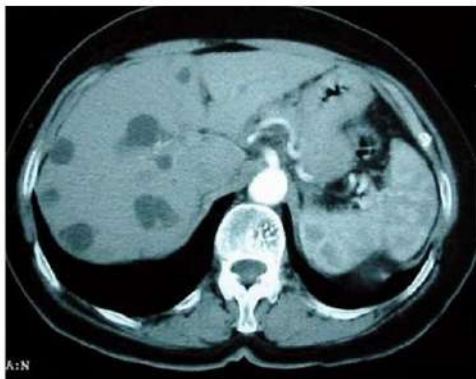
CT scan of the abdominal and pelvic for a patient with hepatic and kidney polycystic disease [8].
